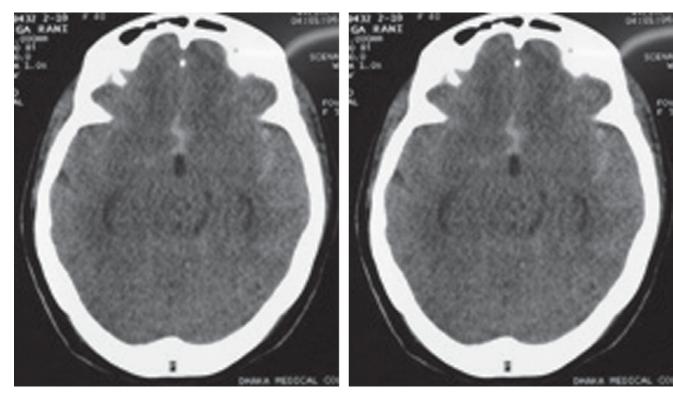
Figure (A): CT scan showed hemorrhage in frontal inter-hemispheric and both Sylvian fissure
